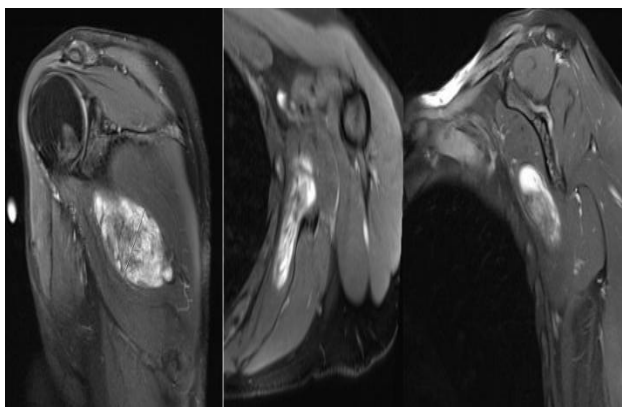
Coronal, axial and sagittal MRI planes of the lesion, respectively.
